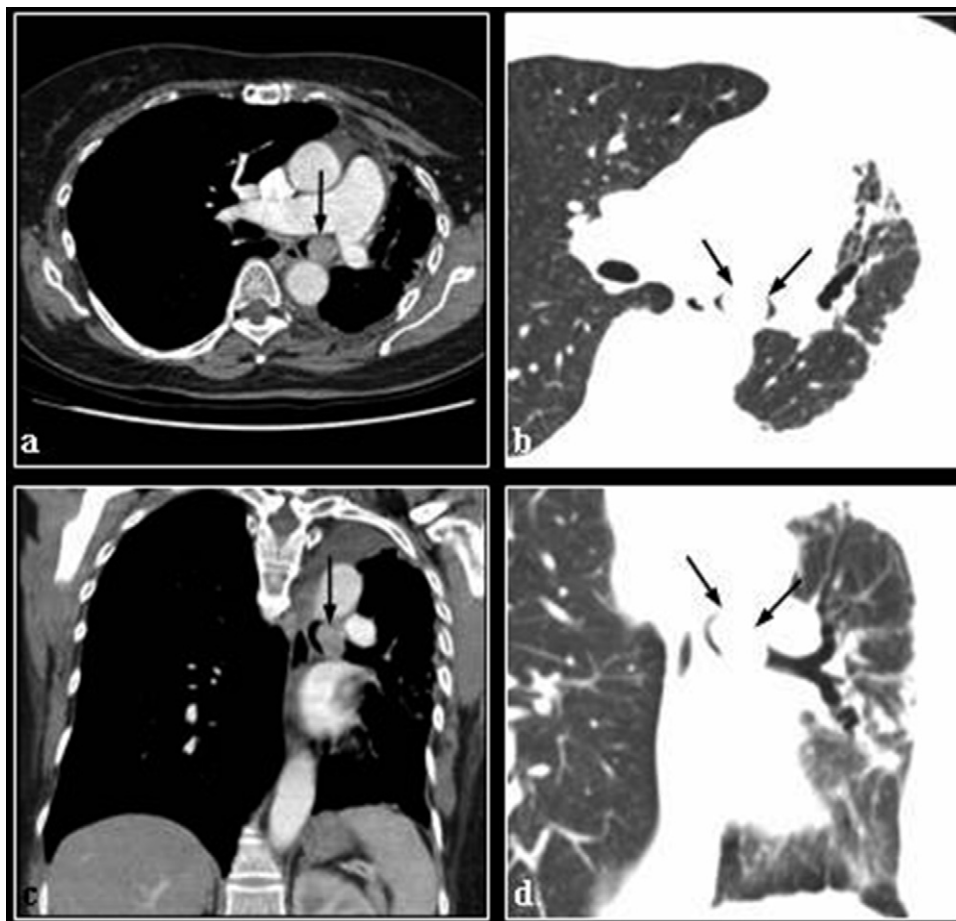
Contrasted CT scan of the thorax in axial views in (a) mediastinal and (b) lung windows and coronal views in (c) mediastinal and (d) lung windows. There is significant volume loss of the left lung with traction bronchiectasis and associated mediastinal shift to the left as well as compensatory hyperinflation of the right lung. There is a well defined, ovoid endobronchial mass with calcifications measuring $2.0 \text{ cm} \times 1.5 \text{ cm}$ in the left main bronchus (arrows).
